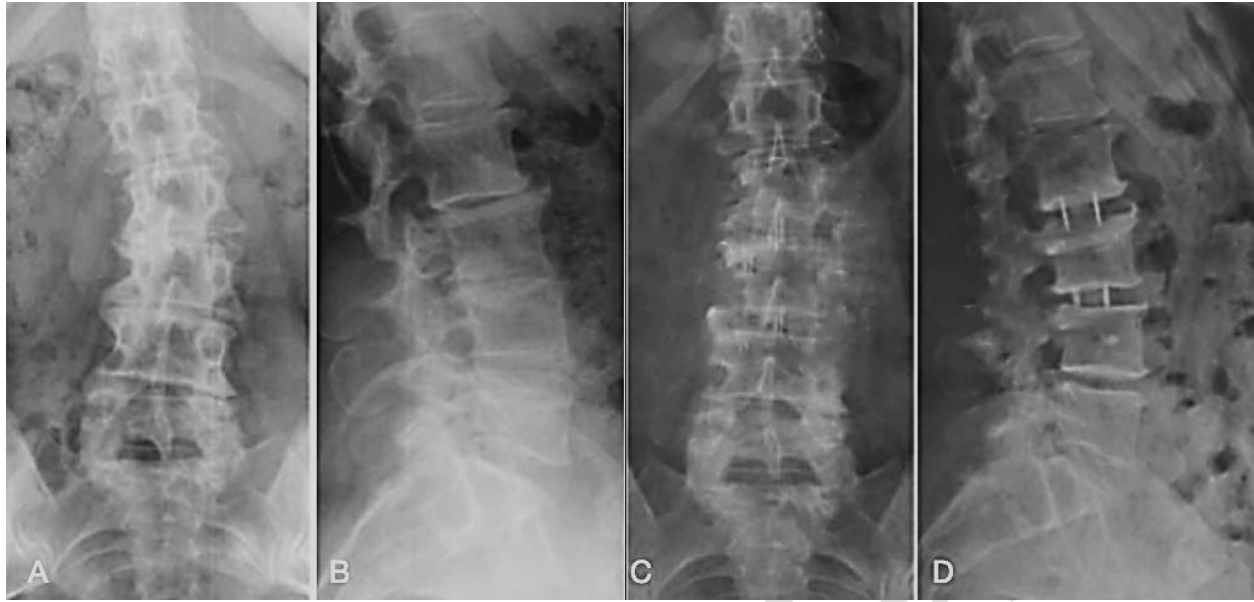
Case 3; 31 old male patient with degenerative scoliosis L2/L3 and L3/L4 complaining of back pain and leg pain of 12 months duration A: AP X-ray L/S spine denoting degenerative scoliosis *Cobb angle* 24 degrees, B: Lat. X-ray L/S spine with decreased disc spaces and straightening of lumbar spine, *SVA*: 10 mm, *PT*: 16 degrees, *SS*: 42 degrees, *LL*: 24 degrees, *PI/LL* mismatch: 27 and *anterior disc height*: 7.2 mm L2/3 and 8.3 mm L3/L4 C: AP L/S spine after OLIF levels L2/L3/L4 1-year follow up shows improved *Cobb angle* to 9 degrees, and D: Lateral X-ray L/S spine 1-year follow-up shows increased *anterior disc heights* 11.5 mm L2/L3, 12 mm L3/L4 on L2/L3 and L3/L4, *SVA*: 8 mm, *SS*: 43 degrees, *PT*: 14 degrees, *LL*: 35 degrees and *PI/LL*: mismatch: 18.
